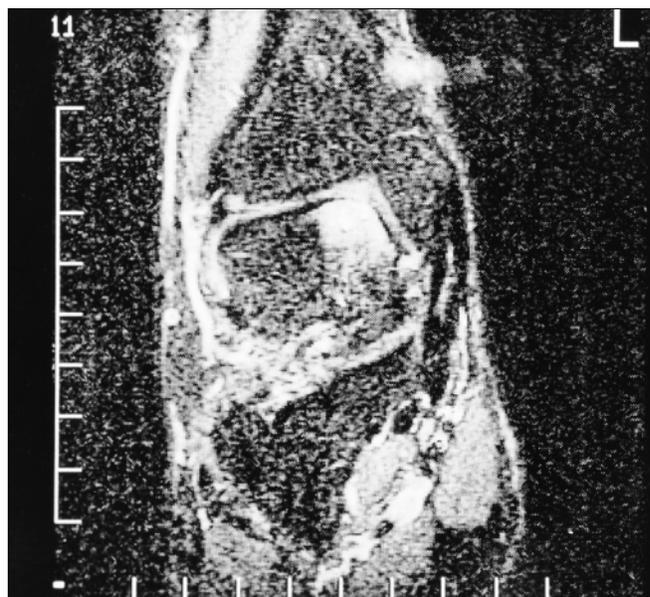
Magnetic resonance imaging (MRI) demonstrates an osteochondral fracture of the superomedial talar dome with adjacent marrow edema.
